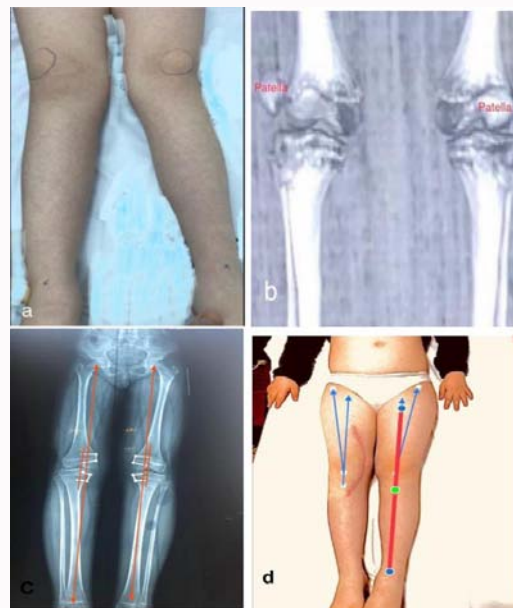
Recurrent dislocation of the right patella and left patellar subluxation in a patient with Down syndrome operated by the Dewar-Galeazzi procedure associated with the Roux-Goldthwait technique (4 interventions during the same surgical intervention); for the bilateral genu valgum, the distal medial hemiepiphyseodesis of the femur and proximal tibia was performed, bilateral. a) Pre-surgery, the clinical examination shows dislocated right patella, subluxated left patella and obvious genu valgum, bilaterally, and CT b) Confirmed the right-side dislocation and left-side subluxation. Post-surgery c) The topogram shows slight hypercorrection in the biomechanical axis, subsequently rectifiable and d) Q angle within normal limits. Left patellar subluxation was corrected by treating genu valgum by hemiepiphyseodesis
